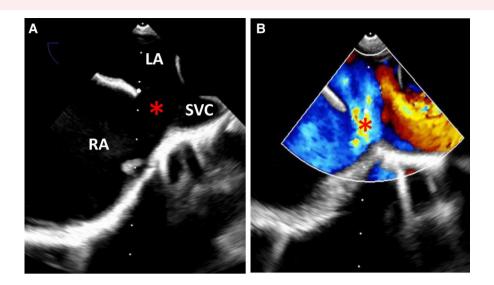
Transoesophageal echocardiography pre-atrial septal defect closure. Two-dimensional (A) and colour-Doppler (B) transoesophageal echocardiography; LA, left atrium; RA, right atrium; SVC, superior caval vein; asterisk indicates the sinus venosus defect.
